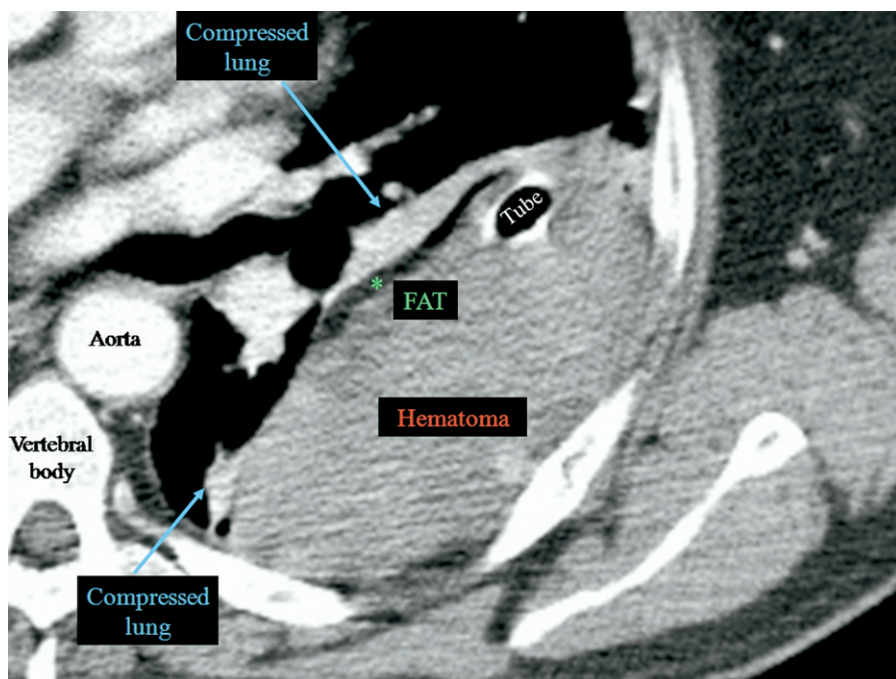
Contrast-enhanced axial CT image demonstrates a large collection of increased attenuation, interpreted as a hematoma, that contains the chest tube separated from the enhancing partially collapsed left lower lobe by a fat attenuation stripe. This fat ribbon is known as the extrapleural fat sign and establishes the extrapleural location of the lesion.
